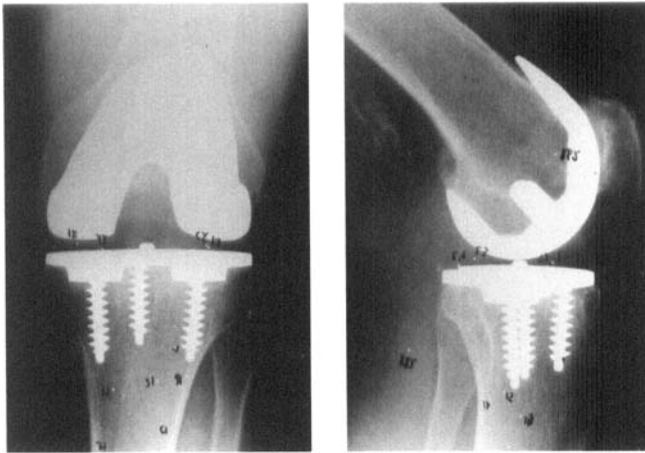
The stress examination where the patient was squatting (position 5). Beyond 60 degrees flexion the A-P radiographic rays were obscured by the buttock of the patients, and thus examination with larger degrees of flexion could not be performed.
